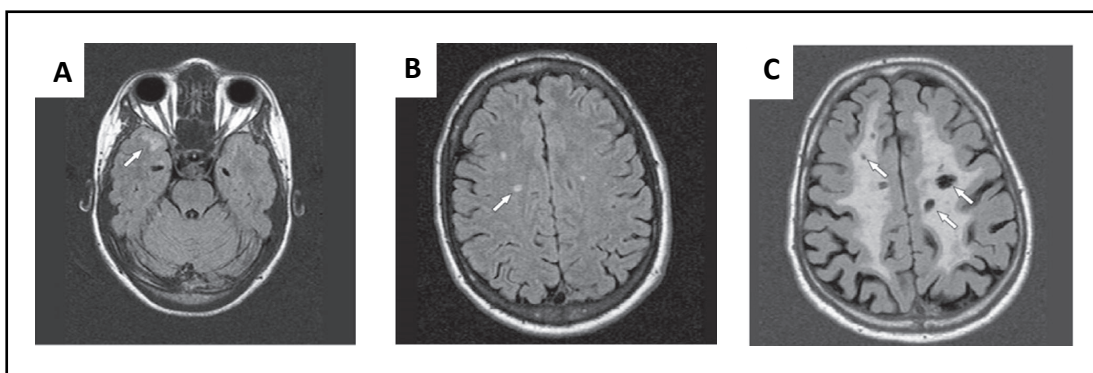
Typical pattern of CADASIL abnormalities on MRI. Fluid Attenuated Inversion Recovery (FLAIR) images showing: (A) discrete circumscribed areas of white matter hyperintensities (WMH) in the anterior temporal lobes (B) discrete circumscribed areas of WMH in the periventricular semioval center (C) extensive areas of confluent and symmetrical WMH and lacunes (adapted from Mancuso et al., 2020)
